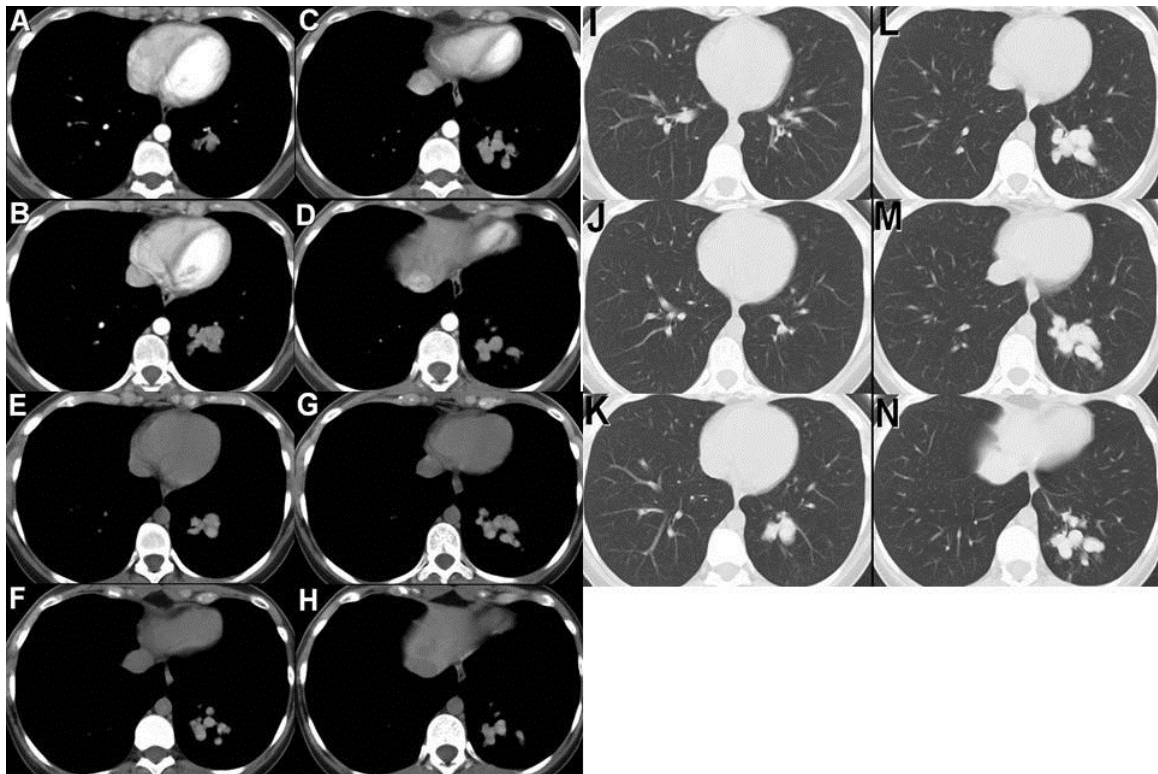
Enhanced (Panels A-D) and unenhanced (Panels E-H) thoracic CT displayed in soft tissue windows. Axial thoracic CT displayed in lung windows (Panels I-N).
